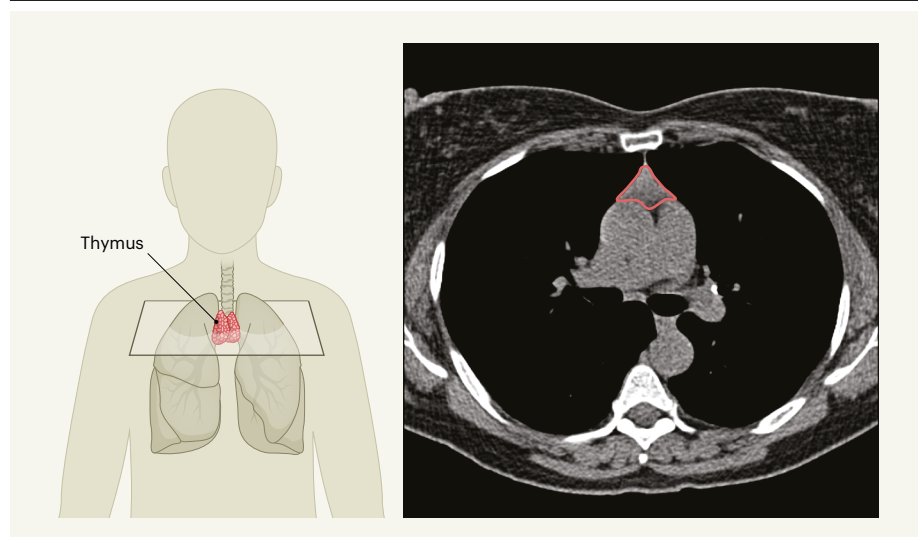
Assessing the thymus in adults. Bernatz *et al.*^{3,4} examined the relationship between an organ called the thymus and disease susceptibility and responses to cancer treatment in adults. The authors analysed the organ's size as a way to assess its health, using scans called computed tomography (CT) images (left panel shows the thymus position and the angle of the CT cross-section through the body; right panel shows an example CT image with a large thymus outlined in red). Having a larger thymus correlated with better health and better immunotherapy outcomes. (Adapted from Fig. 1 of ref. 3.)
